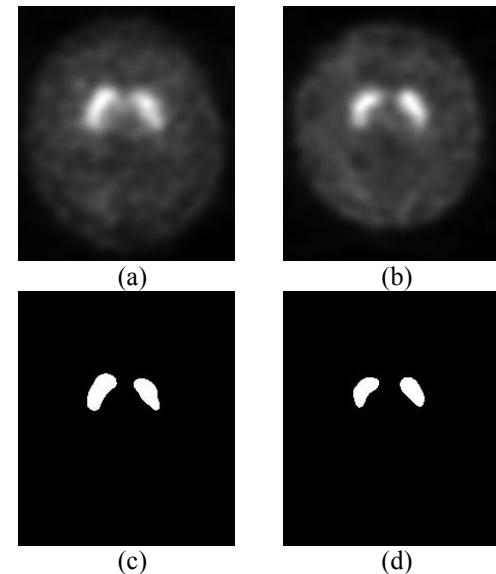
(a - b) representative sets of healthy control SPECT images and their corresponding segmented striatum region (c-d)
